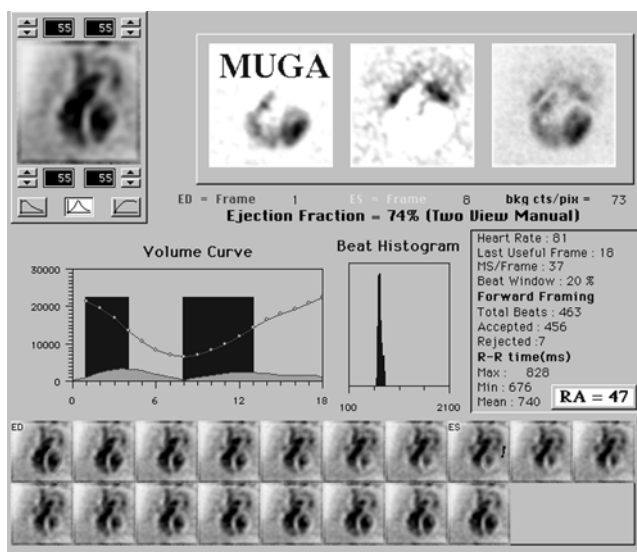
EF Measurement in SPECT.
